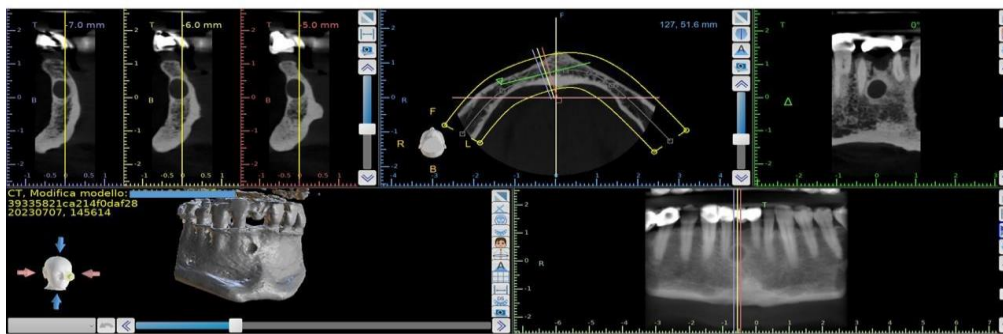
TAC Cone Beam 3D showed radiolucency in anterior mandible.
